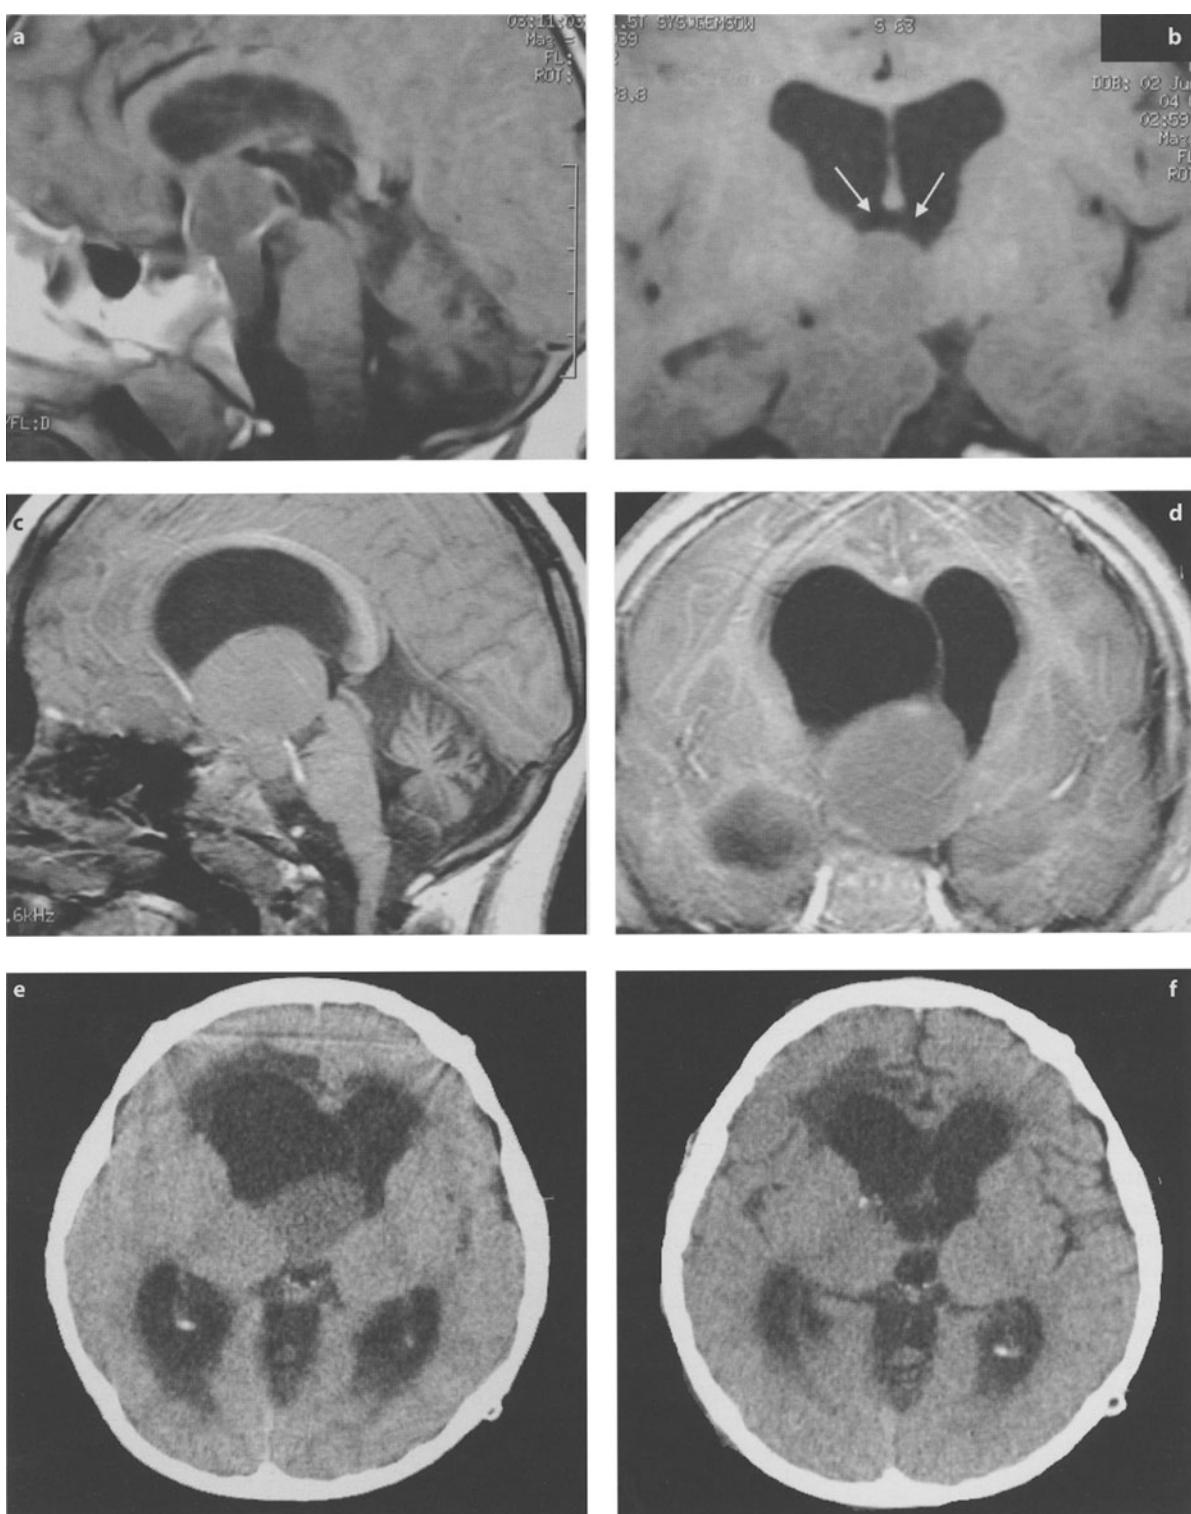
Recurrence of cystic craniopharyngioma: a Sagittal and b coronal T1-weighted images 4 months following incomplete removal of the lesion in another department. The tumor cyst is regrowing, but the posterosuperior part of the third ventricle and the two foramina of Monro (arrow) are free. Three months later, the volume of the cyst has increased, filling the third ventricle (c) and occluding both foramina of Monro (d), the right one before the left one, inducing asymmetric hydrocephalus. e, f CT scan at the time of c and d (e) and following endoscopic fenestration and aspiration of cyst fluid (f). This maneuver is always sufficient to resolve hydrocephalus before tumor removal
